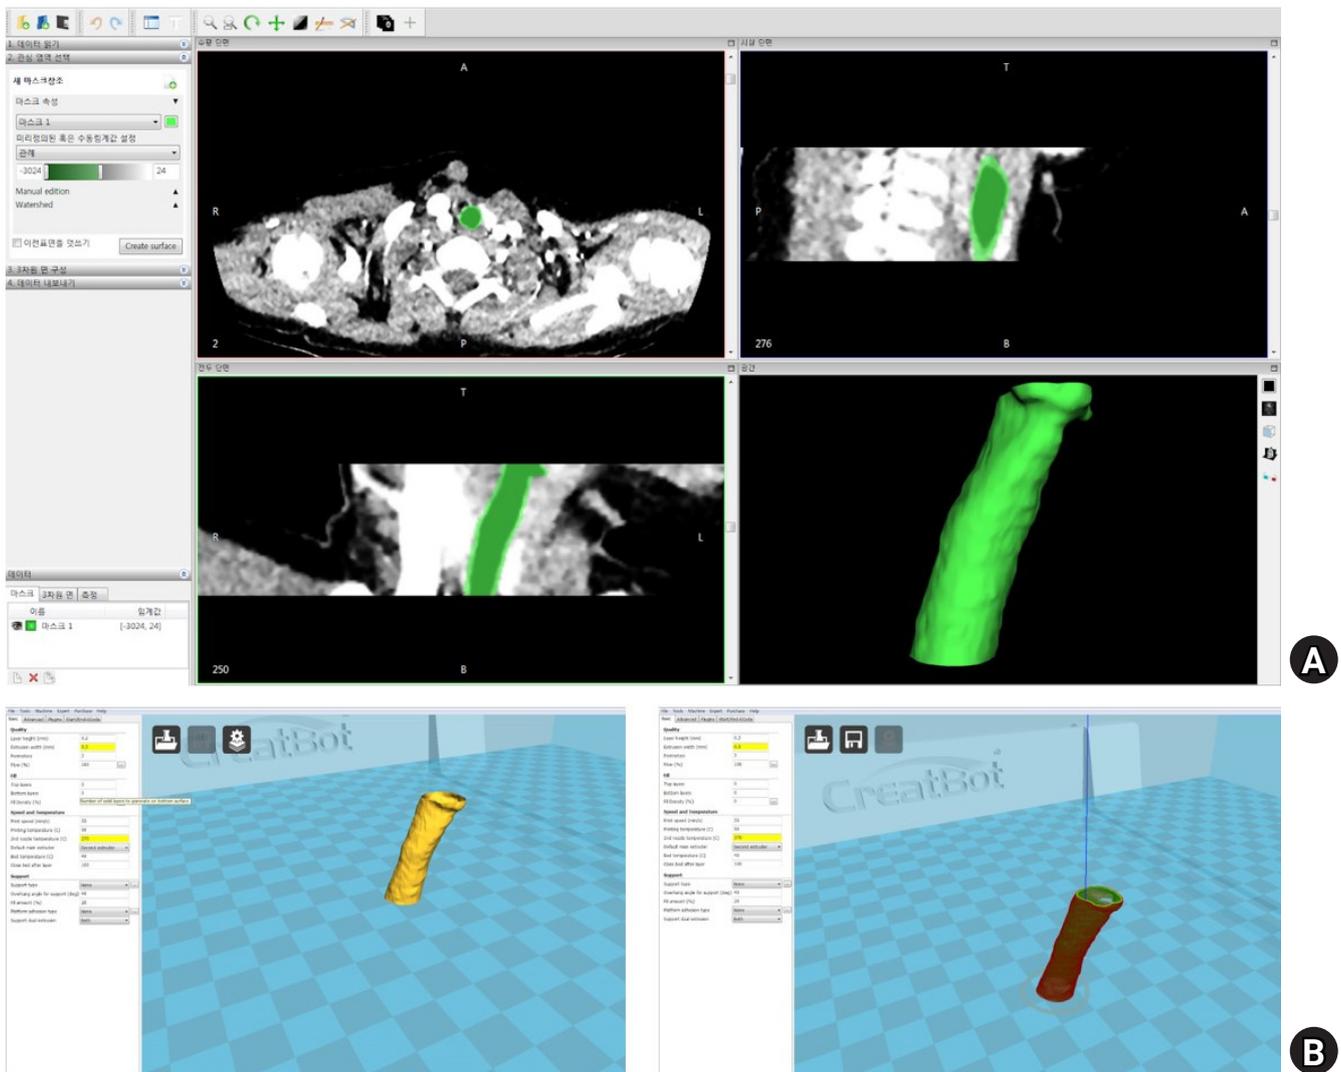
The methods for conversion of image from CT. (A) DICOM files of pediatric patients CT images were converted to STL files using the 3D conversion software-open source program InVersalius (InVersalius 3.0, Renato Archer Information Technology Center, Brazil). (B) The STL files were converted to G-Code files for 3D printing using CreatWare 6.4.6 (CreatWare 6.4.6, Henan Suwei Electronic Technology Co., Ltd., China). CT: computed tomography, DICOM: Digital Imaging and Communications in Medicine, STL: Standard Triangle Language, 3D: three-dimensional.
